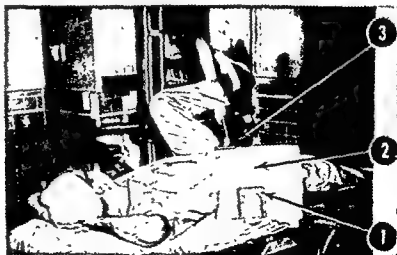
Metal book end (1) supports x-ray cassette (2) in sterile pillow case fastened to sterile drapes with paper clamp (3).
